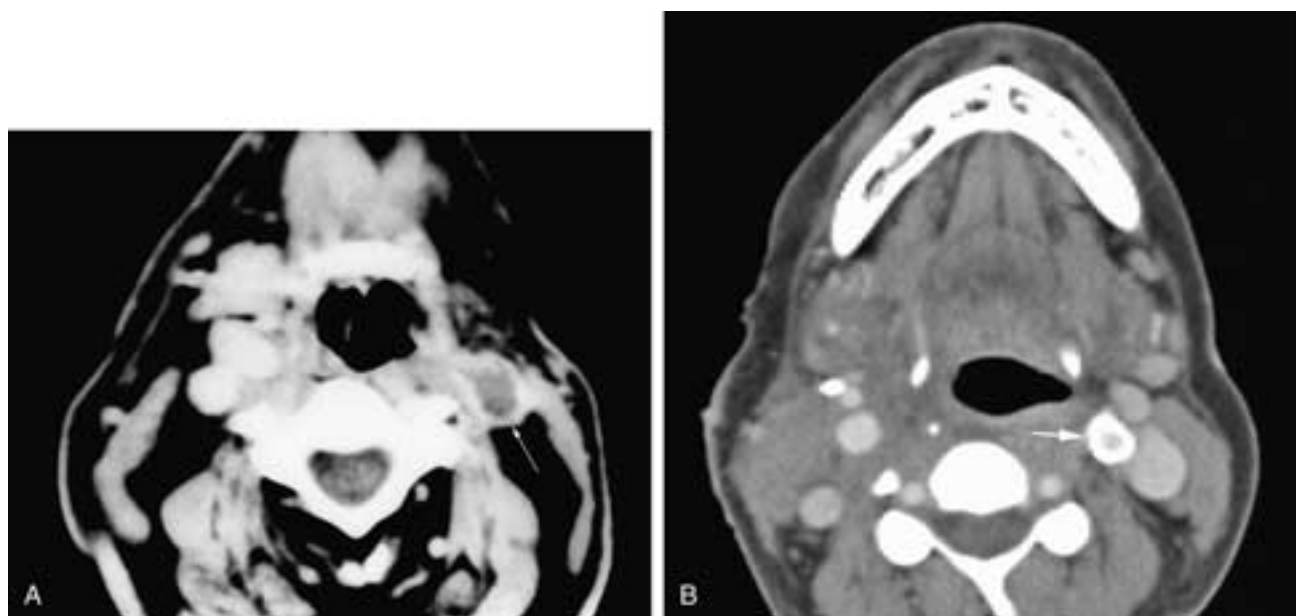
Axial contrast-enhanced CT scan (A) on a patient who has had a left modified neck dissection. The IJV has been resected, but the SCM is present. There is clinically silent thrombosis of the left carotid artery (*arrow*). Axial CT scan (B) on another patient who has had a prior left carotid stent placed (*arrow*). The soft-tissue fullness in the right neck deep to the SCM is related to a recent right-sided endarterectomy.
